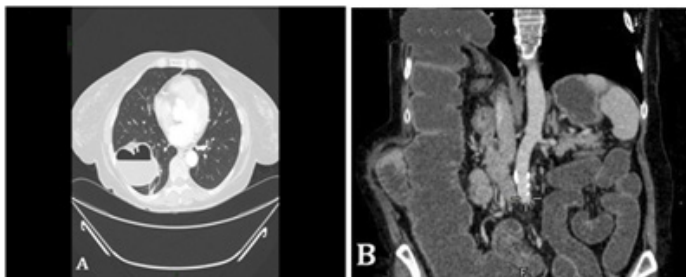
Thoracoabdominal CT with intravenous contrast: 1A coronal cut, 1B sagittal section. Intestinal obstruction in relation to the transverse colon herniation through defect in right diaphragm.
